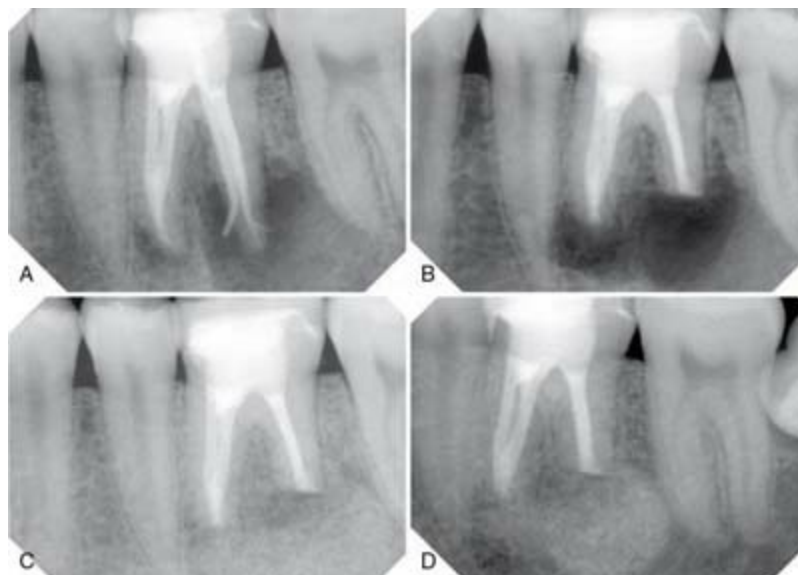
A, Preoperative radiograph of a mandibular left first molar. Gutta-percha was inserted into the buccal sulcus and traced to the apex of the distal root. Nonsurgical root canal treatment had been performed 12 months earlier. B, Root-end resection and MTA root-end fillings (M and D roots). C, Immediate postoperative radiograph. BioOss xenograft material was placed. D, The 19-month follow-up radiograph showed good periradicular healing.
